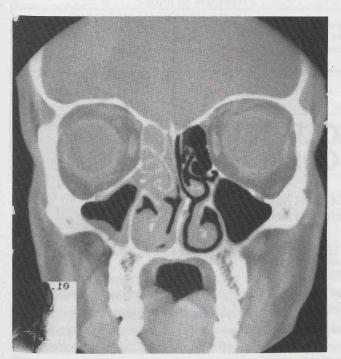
Coronal CT showing unilateral ethmoiditis.
